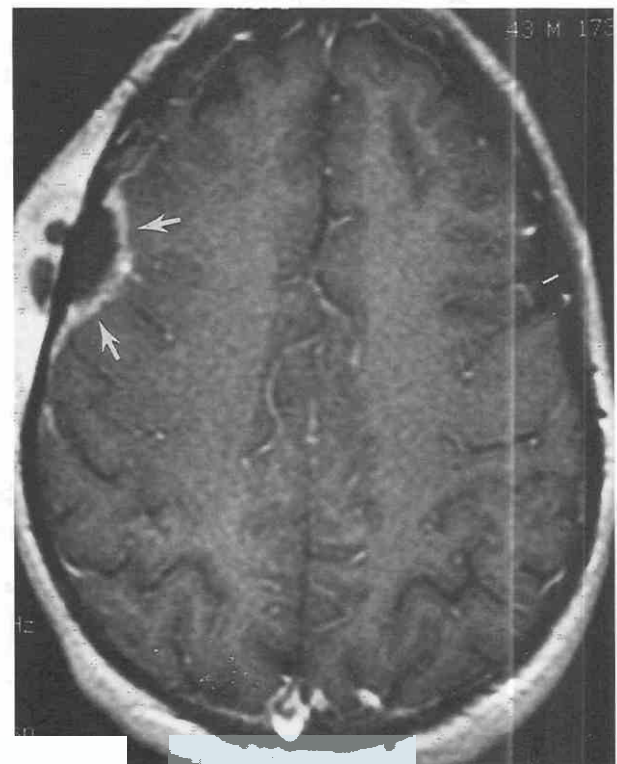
Epidural abscess. Enhanced axial T1-weighted image shows a lentiform epidural collection of pus with dural enhancement (arrows) that could mimic an epidural hematoma.
